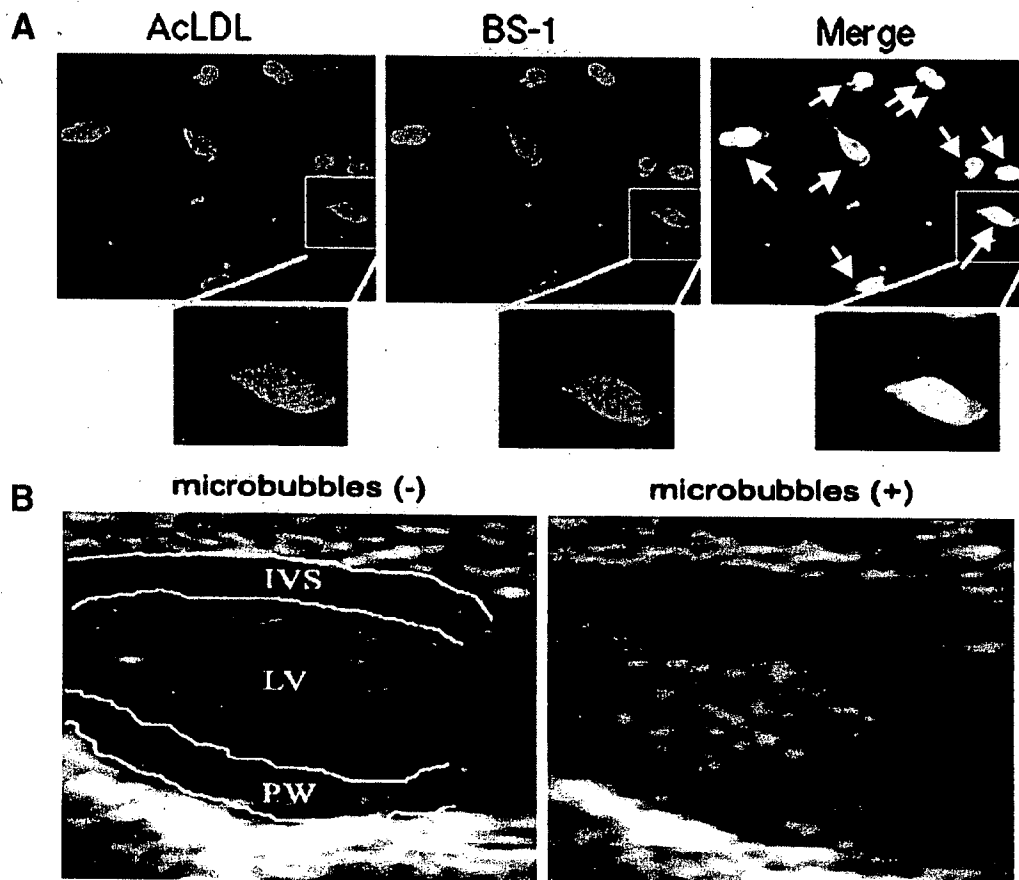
EPC properties of BM-MNCs and the echocardiographic microbubble image. (A) BM-MNCs were cultured on fibronectin-coated plates for 7 days, and their binding ability to FITC-BS-1-Lectin and uptake of DiI-AcLDL was examined. BS-1+/AcLDL+ double fluorescent cells (arrows) in the merged image are considered to be the endothelial-lineage cells that exhibit a spindle shape. (B) The echocardiographical image (arrows) of microbubble delivery into the LV cavity immediately after microbubble injection. LV: left ventricle, IVS: intra-ventricular septum, PW: posterior wall. Scale bar indicates 100 μ m.
